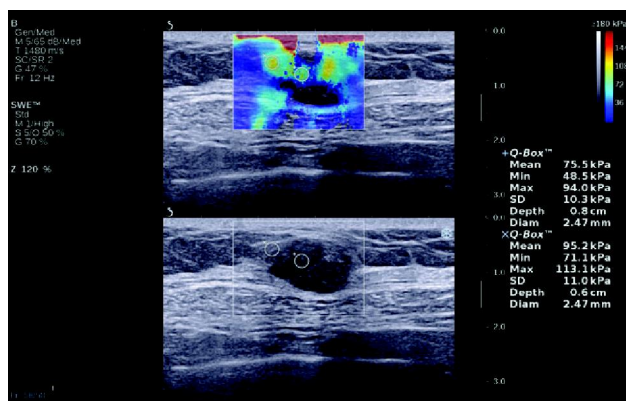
SWE and grayscale ultrasound of a malignant lesion. Shear wave imaging showed a heterogeneous color map (stiff) with E_{mean} of 75.5kPa. Gray scale B-mode ultrasound showed a lobulated hypoechoic lesion.
